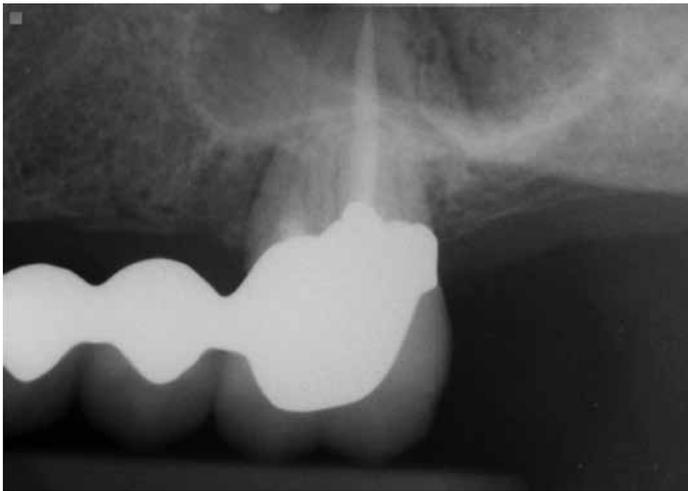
Immediate postoperative radiograph demonstrating resection of the affected root, retrofill of the orifice, and grafting of the osseous defect
